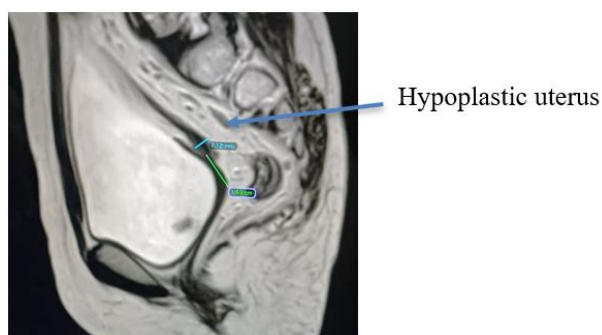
MRI hypoplastic PELVIS- showing hypoplastic uterus measuring 1.7x0.7cms
